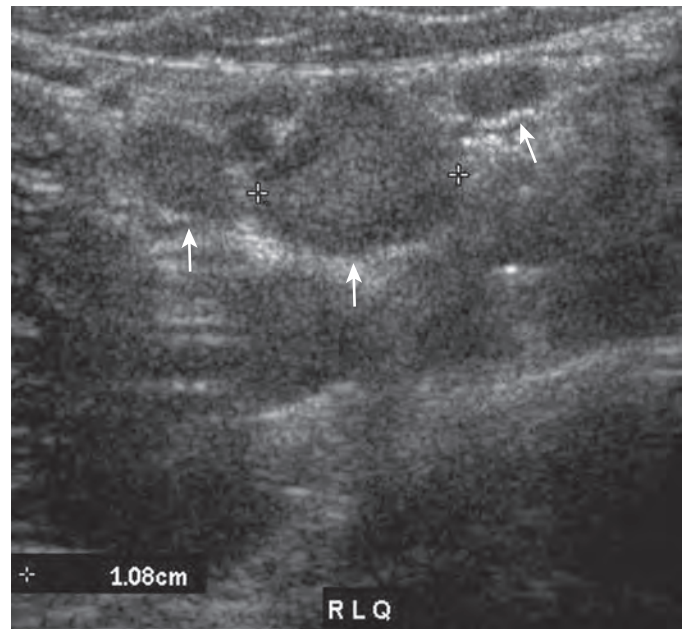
Mesenteric adenitis: ultrasound features.
